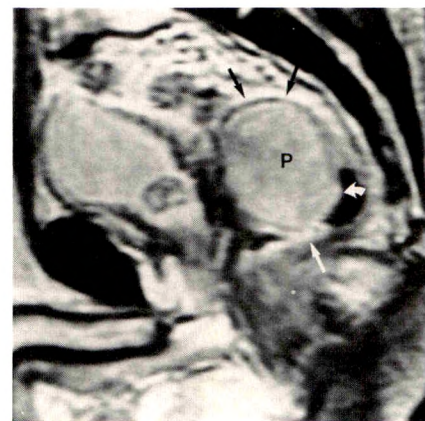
T2-weighted sagittal MR scan of pelvis shows huge prostatic carcinoma (P) obliterating lumen of rectosigmoid colon (black arrows) and rectum (straight white arrow). Original rectosigmoid junction is shown (curved arrow). This sagittal view shows marked cranial growth of tumor into region of seminal vesicles with invasion of rectosigmoid colon.
